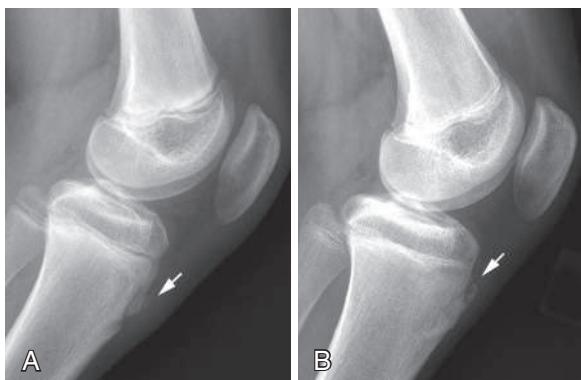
Radiographic findings of Osgood-Schlatter disease. A, Lateral radiograph of the knee of a 13-yr-old male demonstrates a sliver of new bone formation (arrow) at the tibial tubercle. B, Lateral radiograph of the same child at 15 yr of age demonstrates characteristic fragmentation (arrow) of the tibial tubercle.
